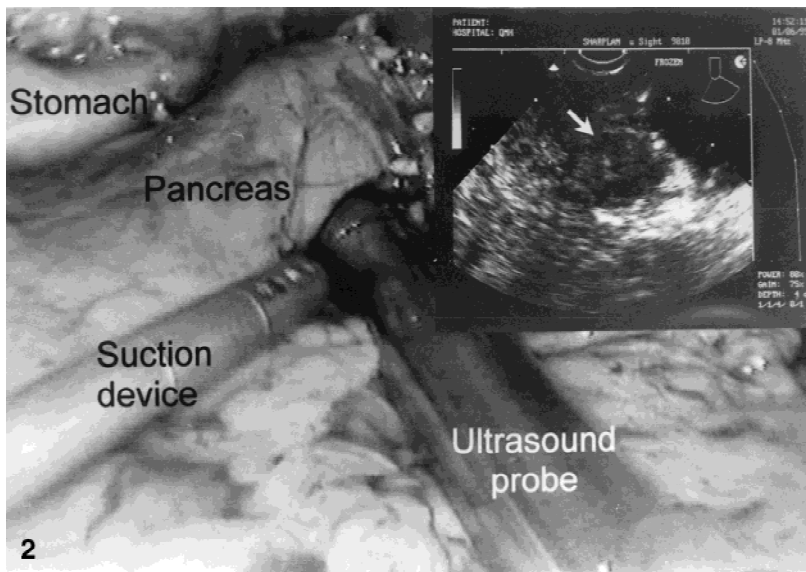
Laparoscopic ultrasonography confirms the position of a hypoechoic insulinoma at the tail of the pancreas (*arrow*) before distal resection. Note that the irrigation and suction device is used to provide a pool of water as a contact media to facilitate ultrasonographic examination.
